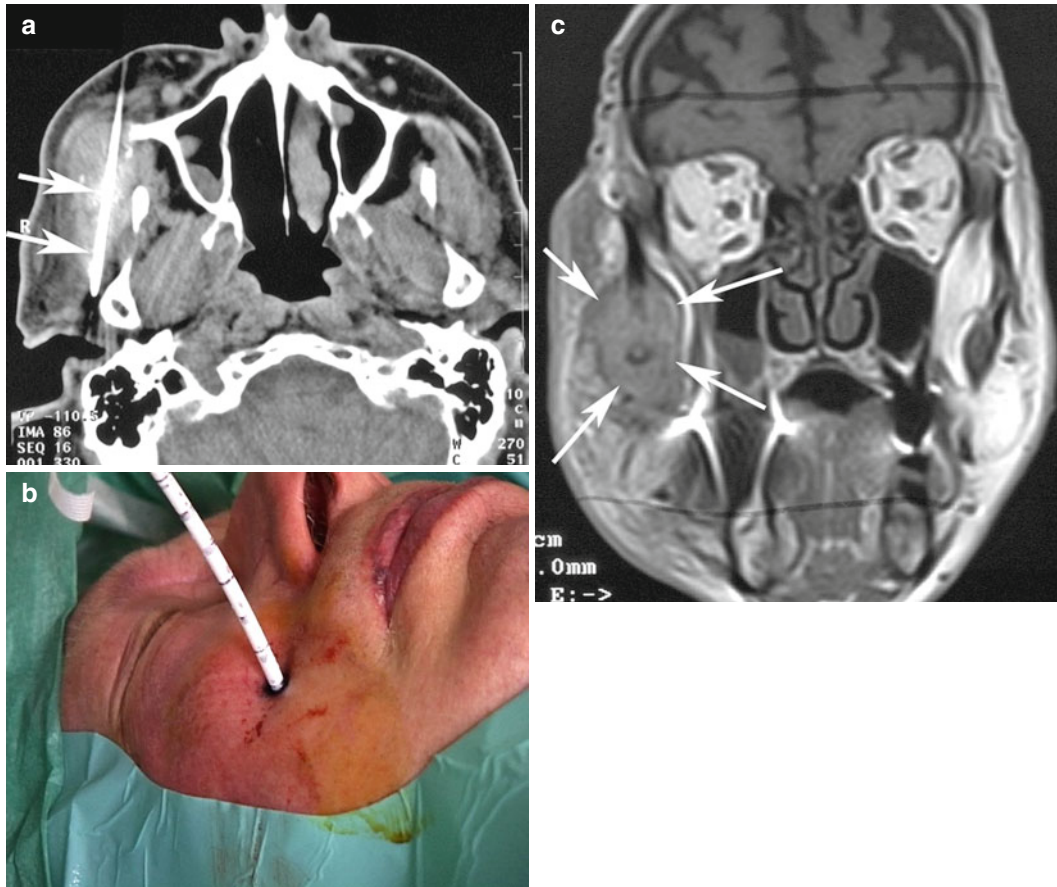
Metastases of a hepatocellular carcinoma in the masticator space. (a) CT-guided puncture of the lesion. Note the positioning of the needle (*arrows*). (b) The clinical image shows the laser application system in situ using
